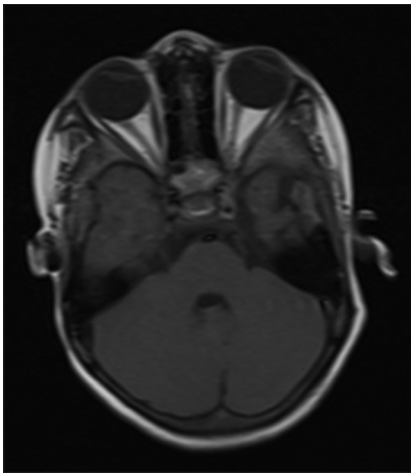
T1W MRI images showing left hypertrophy of frontal and mastoid air sinuses
